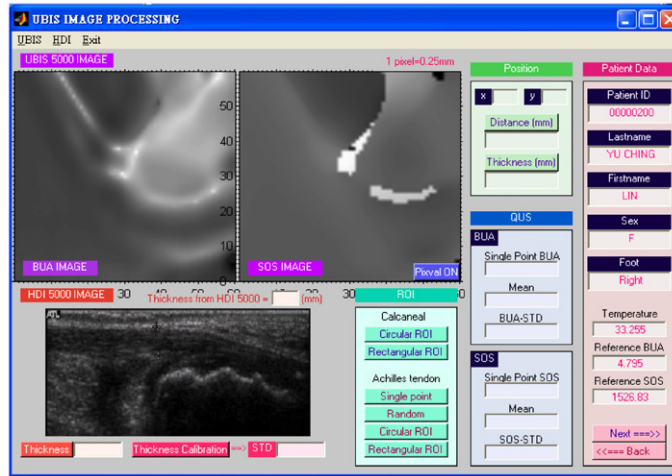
Parametric and B mode ultrasonic images of the Achilles tendon from images obtained by (a) UBIS 5000 and (b) HDI 5000, respectively.
